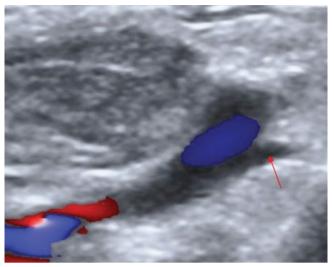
Ultrasonography of the jugulo-subclavian angle. Thoracic duct (red arrow)
